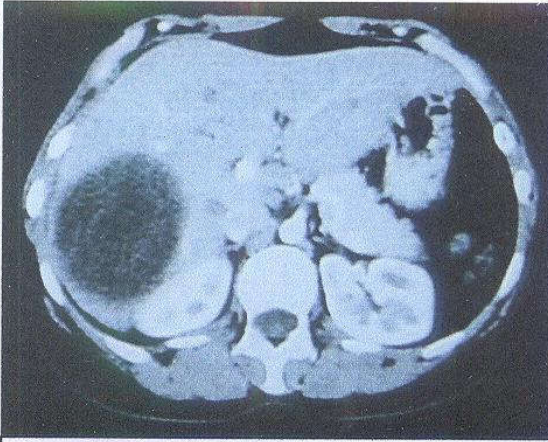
CT scan showing hydatid cyst in the right lobe of the liver
